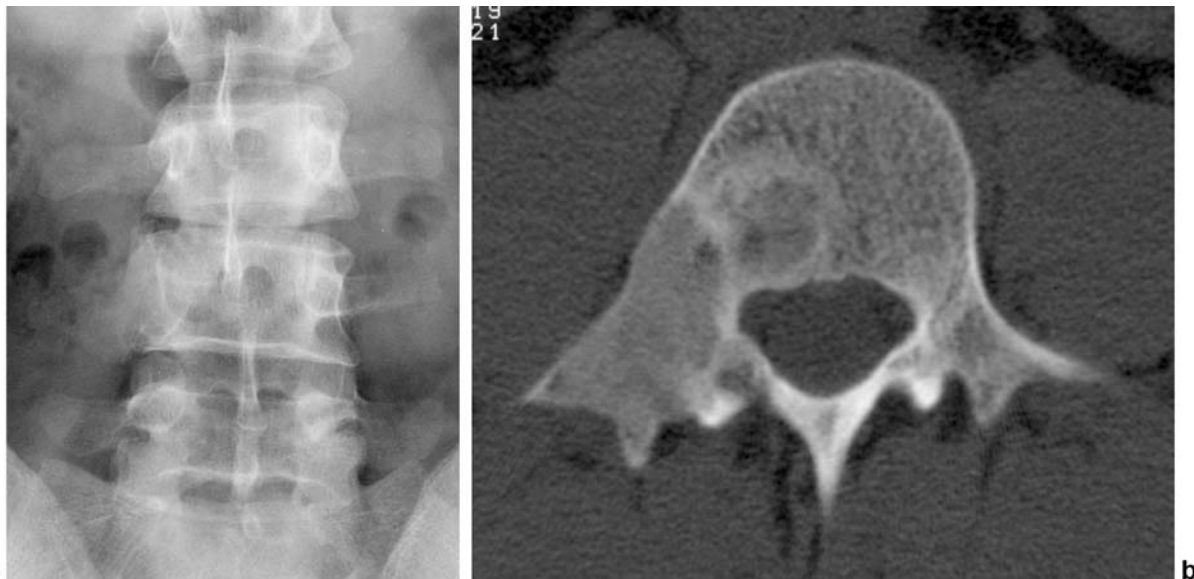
(a) Anteroposterior radiograph and (b) transverse computed tomography of the lumbar spine showing an expansile lesion with a ground-glass matrix arising in the right pedicle and transverse process of L4. The imaging is typical but the site atypical for fibrous dysplasia.
